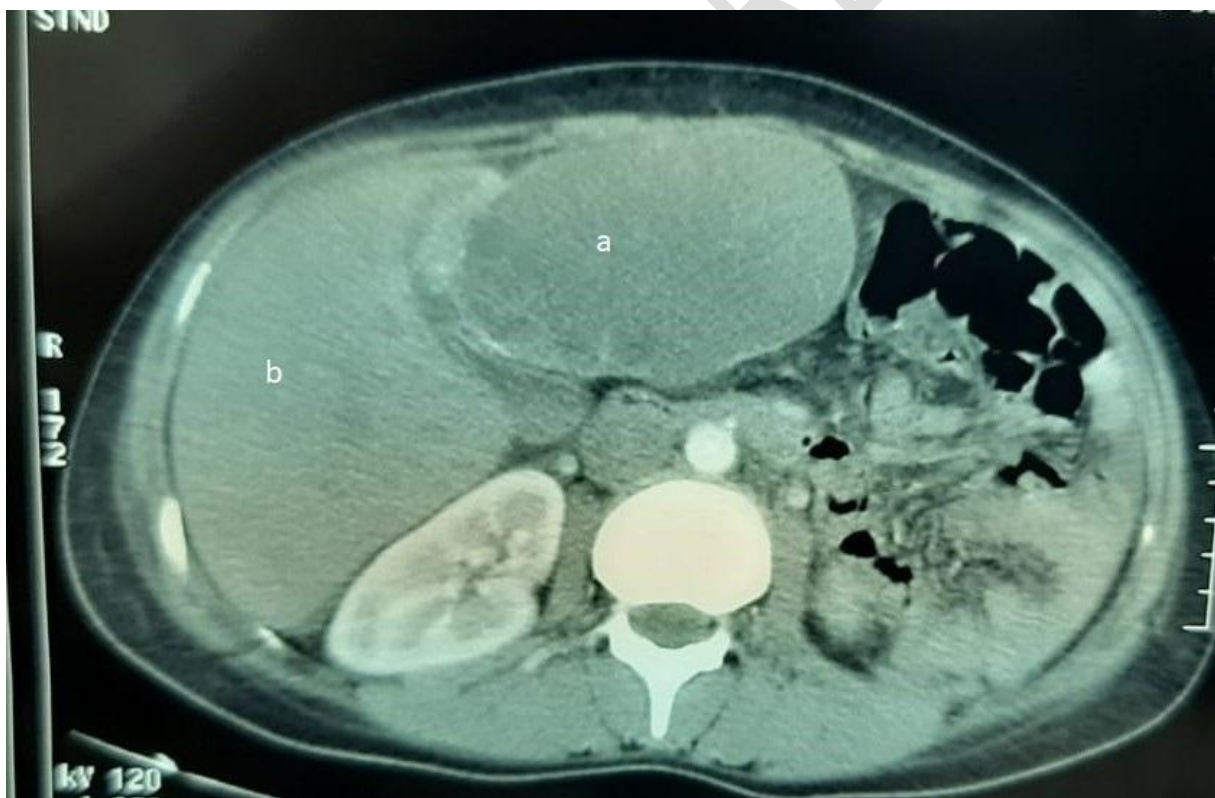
Abdominal CT scan showing a hydatid cyst of the left lobe of the liver
